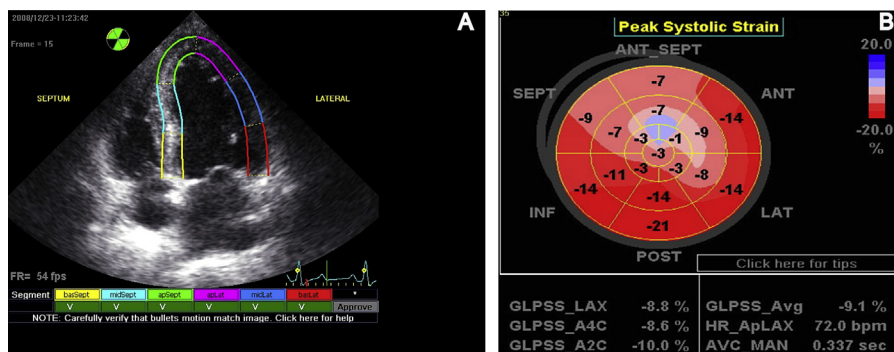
Processing and presentation of global left ventricular peak systolic longitudinal strain (GLS). Values of the peak systolic longitudinal strain from the apical long-axis, apical four-chamber, and apical two-chamber views were obtained from automated function imaging software. (A) Tracking quality approval screen: segments with adequate tracking are shown with a “V” mark. (B) The average value of peak systolic longitudinal strain in each segment calculated from three apical views was used to generate a parametric display, named GLS. A2C = apical two chamber; A4C = apical four chamber; apLat = apical lateral wall; apSept = apical septum; basLat = basal lateral wall; basSept = basal septum; GLPSS = global longitudinal peak systolic strain; LAX = apical long-axis; midLat = mid-lateral wall; midSept = mid-septum.
